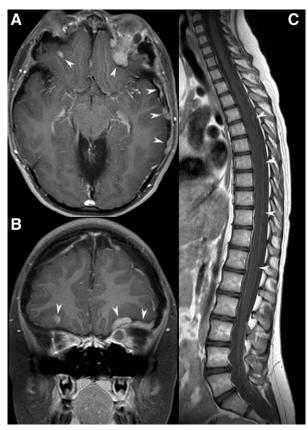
Axial (A) and coronal (B) contrast-enhanced fat-suppressed T1-weighted images of the brain show diffuse enhancing pachymeningeal thickenings (*arrowheads*). C, Sagittal contrast-enhanced T1-weighted image of the spine shows faint meningeal enhancement (*arrowheads*) over the posterior surface of the spinal cord.
